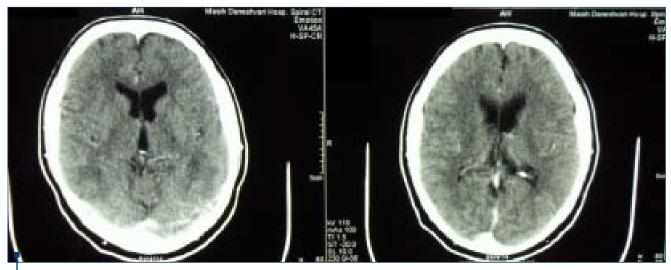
Brain CT with contrast shows no evident lesion. Due to patient's complaints, an MRI was ordered
